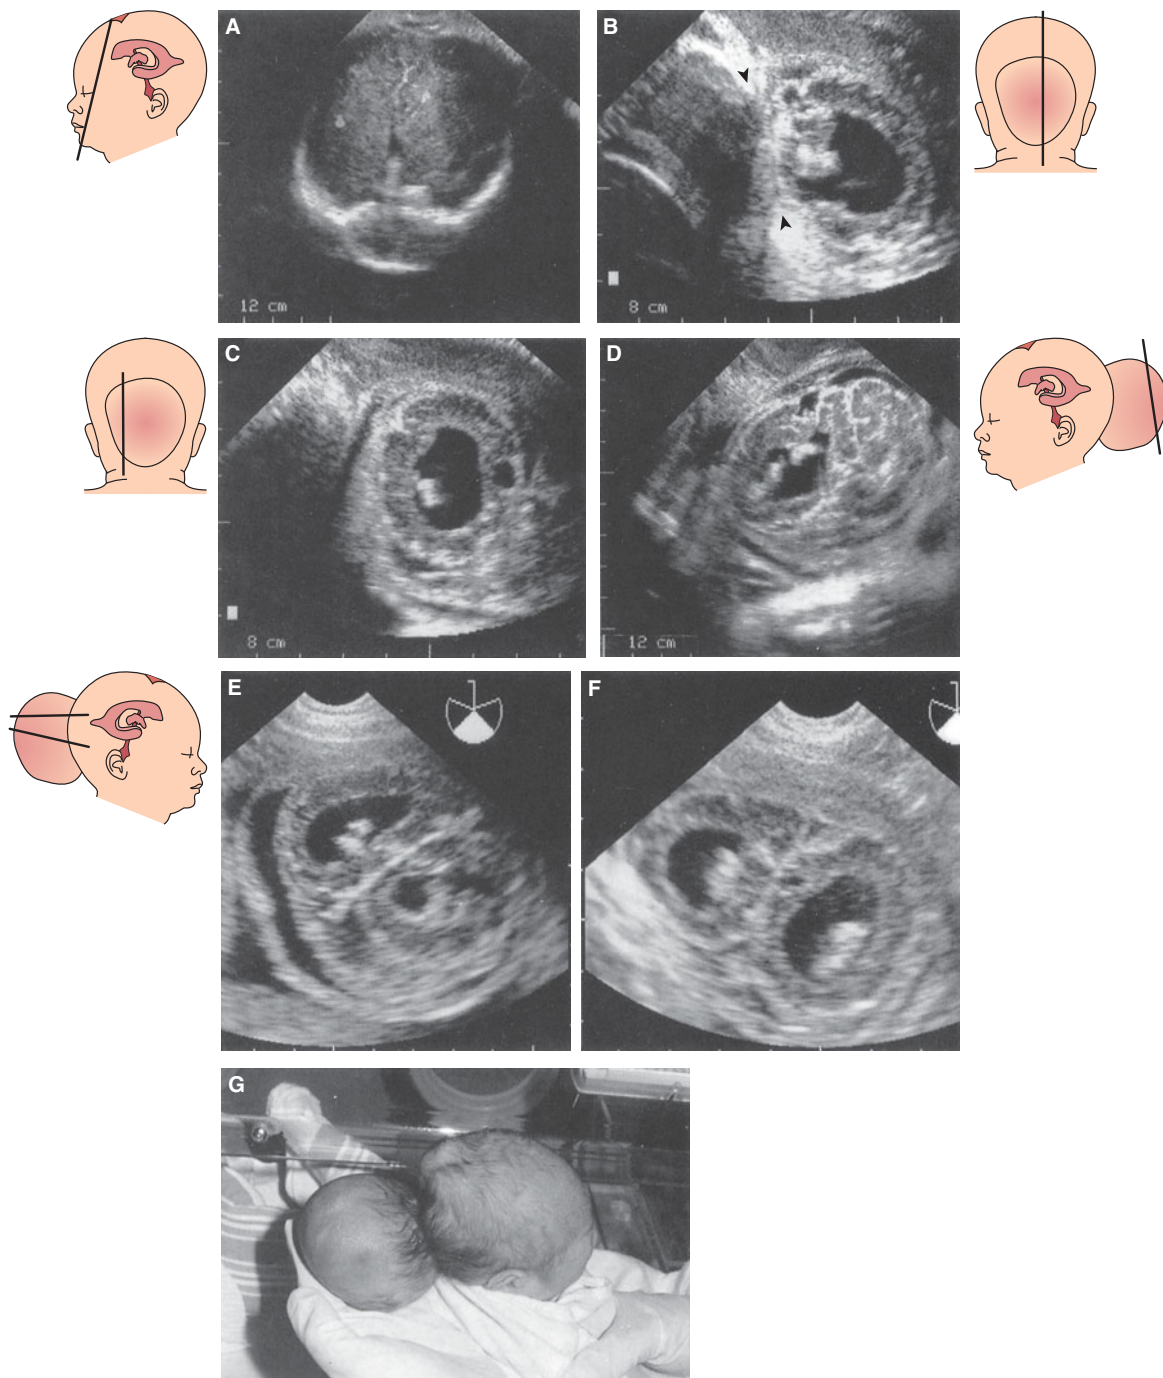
Occipital encephalocele in a fetus at 34 postmenstrual weeks. This patient presented for her first US exam at this gestational age. Microcephaly was also diagnosed (the biparietal diameter [BPD] and the head circumference were consistent with 26 postmenstrual weeks). (A) Frontal-2 section showing the longitudinal sulcus and apparently normal brain tissue. (B) Median section depicting the large bony defect in the occipital region marked by two black arrowheads. Brain tissue seems to protrude, pulling with it the posterior horn and the choroid plexus. (C), (D) Different sections of the encephalocele itself. (E), (F) Coronal sections by definition, showing the longitudinal sulcus and the dilated occipital horns and within it the choroid plexus. (G) A picture of the neonatal head showing the large occipital encephalocele. Clinical course: The neonate was found to have a chromosome 13q deletion and was admitted and discharged several times but reached the age of 1½ years. Another anomaly included absence of the thumbs. Cranioplasty was performed, which was complicated by wound infection and worsening hydrocephaly. A drain was placed; however, the infant was admitted several times to the hospital because of cerebrospinal fluid leak from the incision site. The infant had severe mental retardation and seizure disorder. The computed tomography (CT) studies showed that the encephalocele included the cerebellar hemispheres and a portion of the posterior horns (as diagnosed by the US pictures), in addition, partial agenesis of the corpus callosum with the splenium virtually absent was seen.
